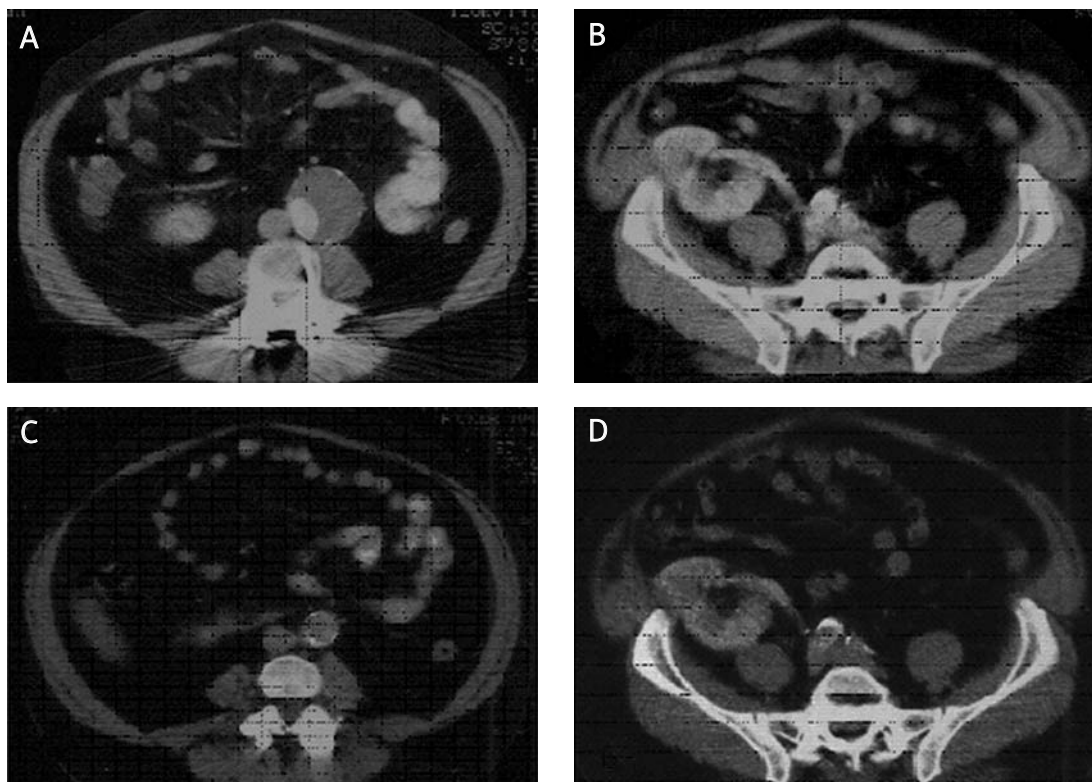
(Case n° 1). Preoperative CT scan shows the infrarenal AAA (A), and the transplanted kidney in the right pelvis (B). Computed tomography scan 1.5 years later showing the aorto-aortic prosthesis (C), and the patent transplant renal artery from the right iliac artery, with adequate parenchymal nephrogram (D)
